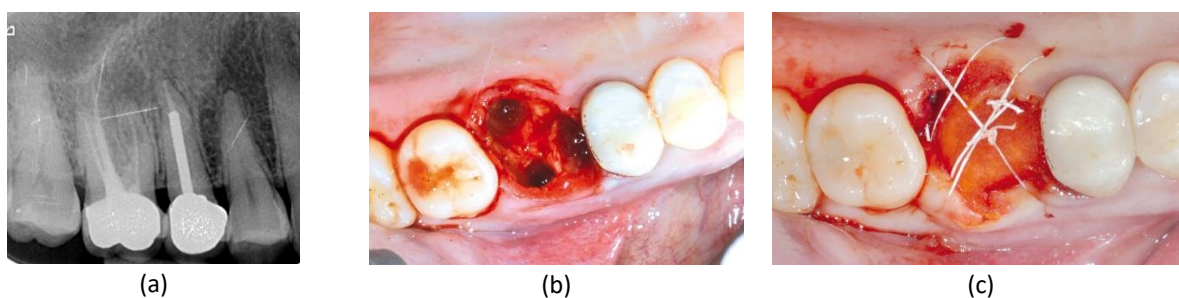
Patient 5: (a) X-ray showing endodontic failure; (b) atraumatic tooth extraction; (c) blood clot stabilization with mucoderm®.
